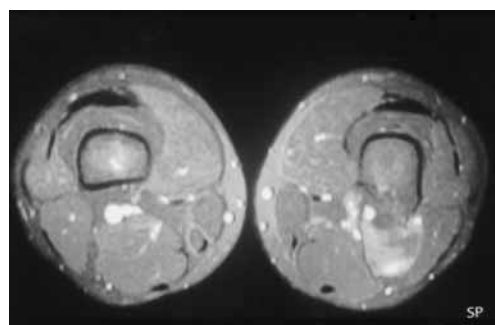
Axial MRI showing the bony protuberance surrounded with a well-defined ovoid mass with high signal intensity.
